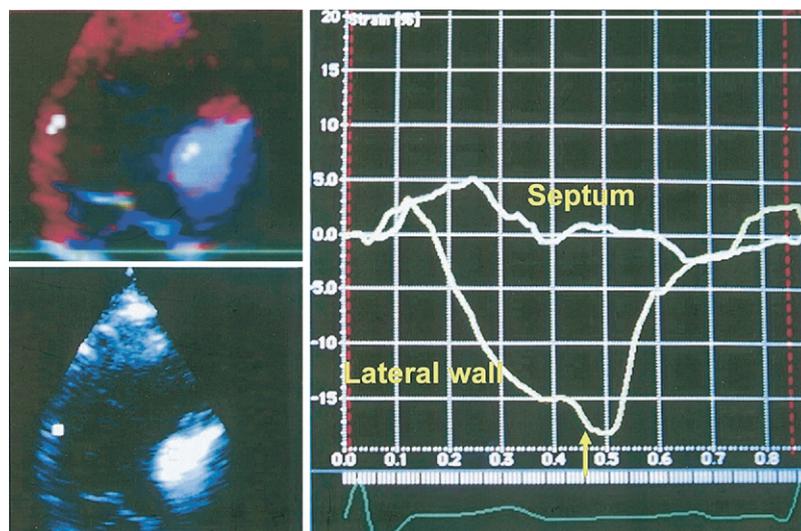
Septal and lateral base function by Doppler strain-time curves, after alcohol injection. Systolic compression is present in the lateral wall, but the base of the septum is dysfunctional. The arrow points to post-systolic compression, which is not uncommon in hypertrophic cardiomyopathy and seems related to abnormal loading conditions and possibly ischemia.
